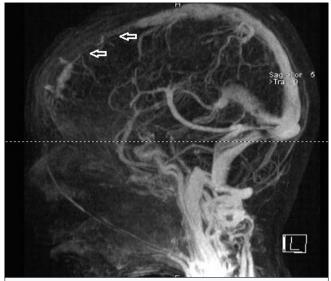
Thrombosis in the anterior superior sagittal sinus in brain magnetic resonance imaging venography scan (white arrows)
